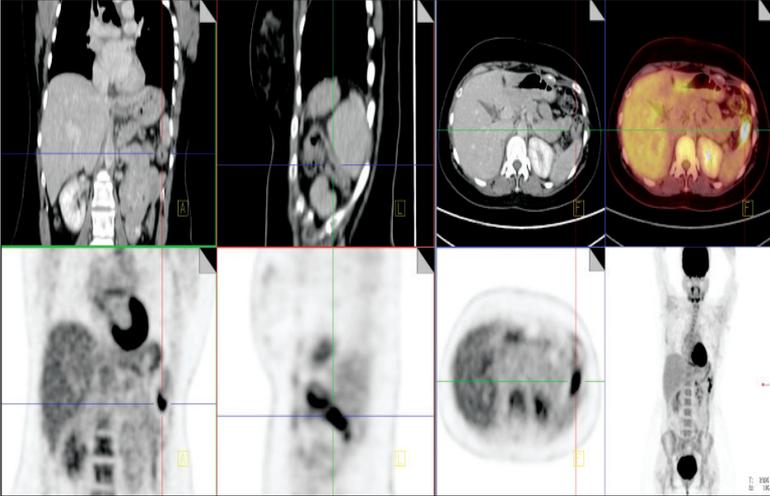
A focal area with high FDG uptake is seen in the left hypochondrial area corresponding to area of inflammation
